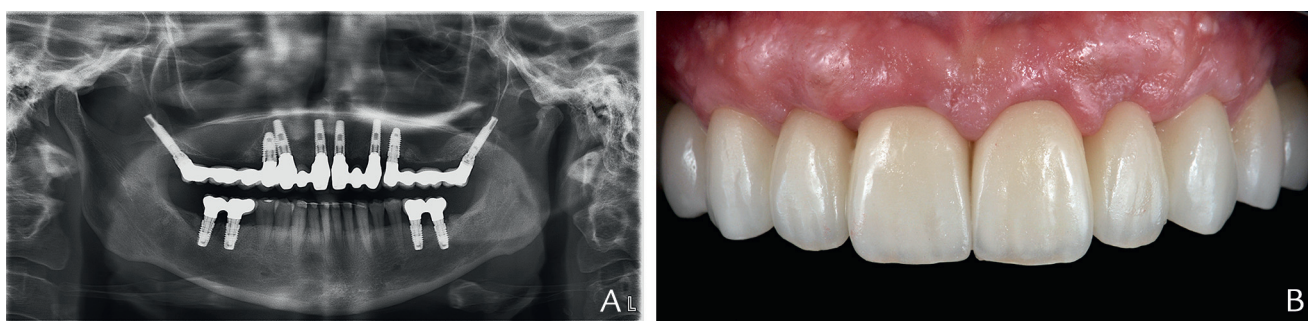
Six-year recall appointment. A, Panoramic radiograph. B, Intraoral view.
